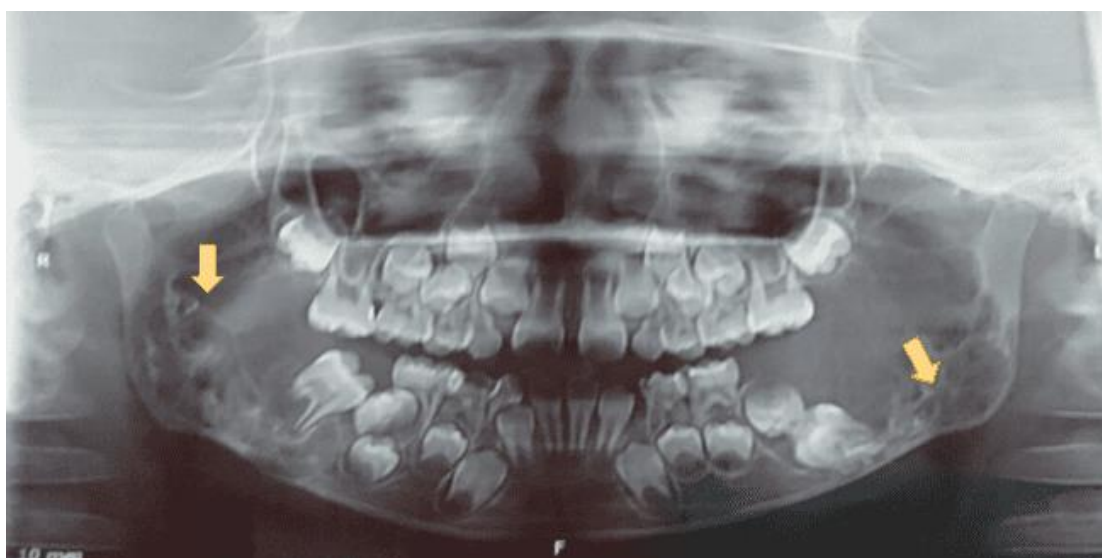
Based on panoramic radiographs, the characteristics appear as ill-defined margins with multiple small radiolucencies. This can manifest as a "moth-eaten" appearance due to the destruction of bone and presence of multiple irregular radiolucent areas within the mandible (Yellow Arrow).
